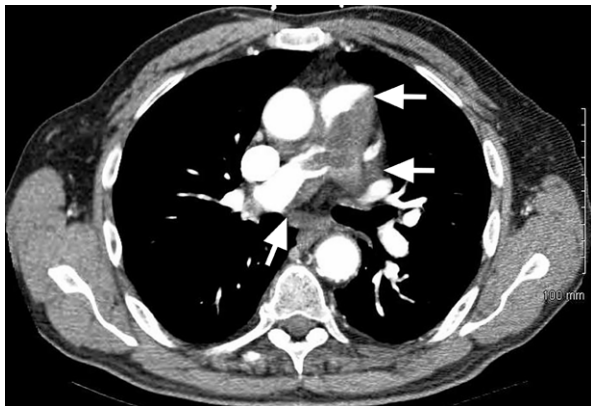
Computed tomogram of the chest shows the tumor mass within the pulmonary trunk and its extensions into the pulmonary artery main branches (arrows).
